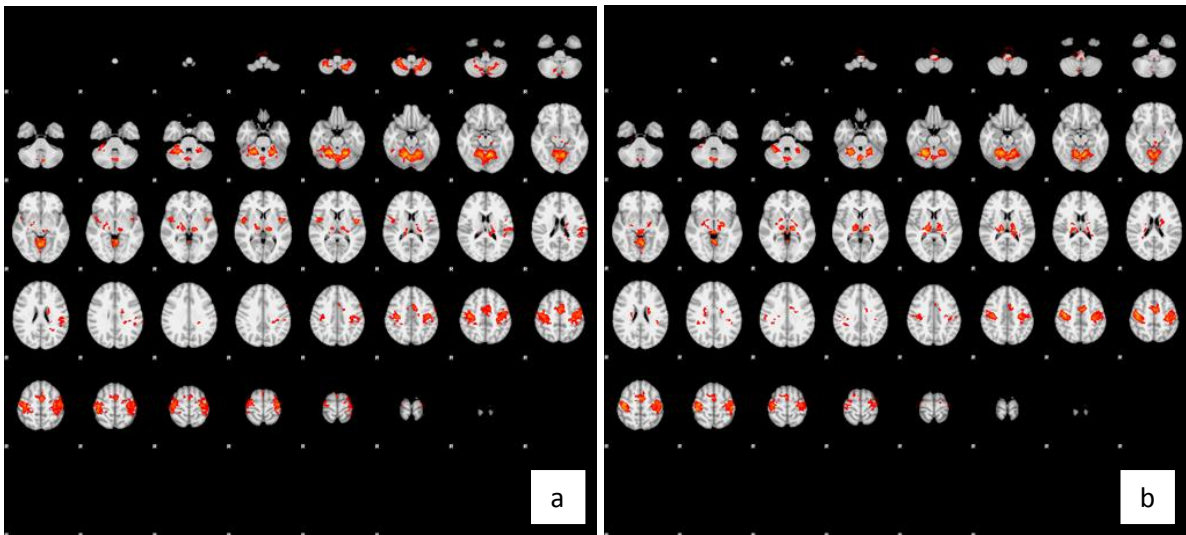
Pre placebo (a) vs. post placebo (b). The orange red marks on a MRI T1 anatomic multiple slices axial template, correspond to areas activated by motor task.
